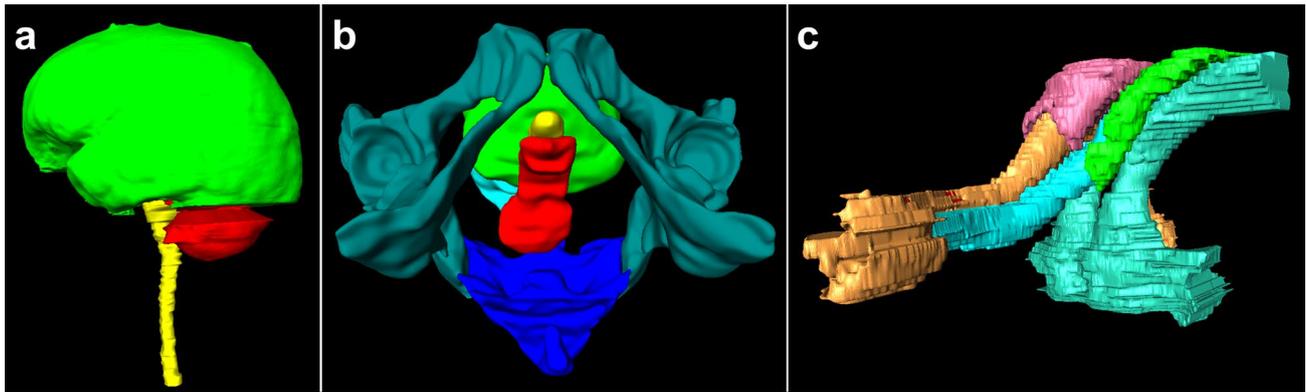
Examples of 3D digital models. a Cerebrum, cerebellum and brain stem from head and neck CT data. b Bladder, urethra, uterus, vagina and pelvic bone from pelvic MRI data. c Ischiocavernosus
